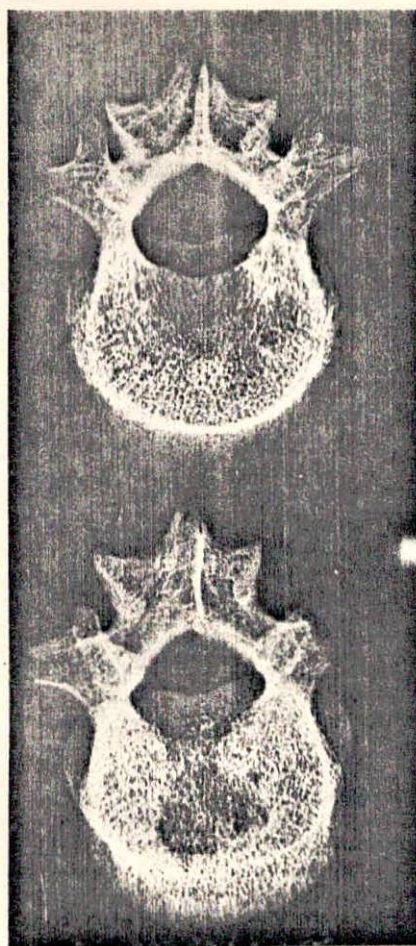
Case 1. Superoinferior roentgenogram of L-2 (top) and L-3 (bottom).
